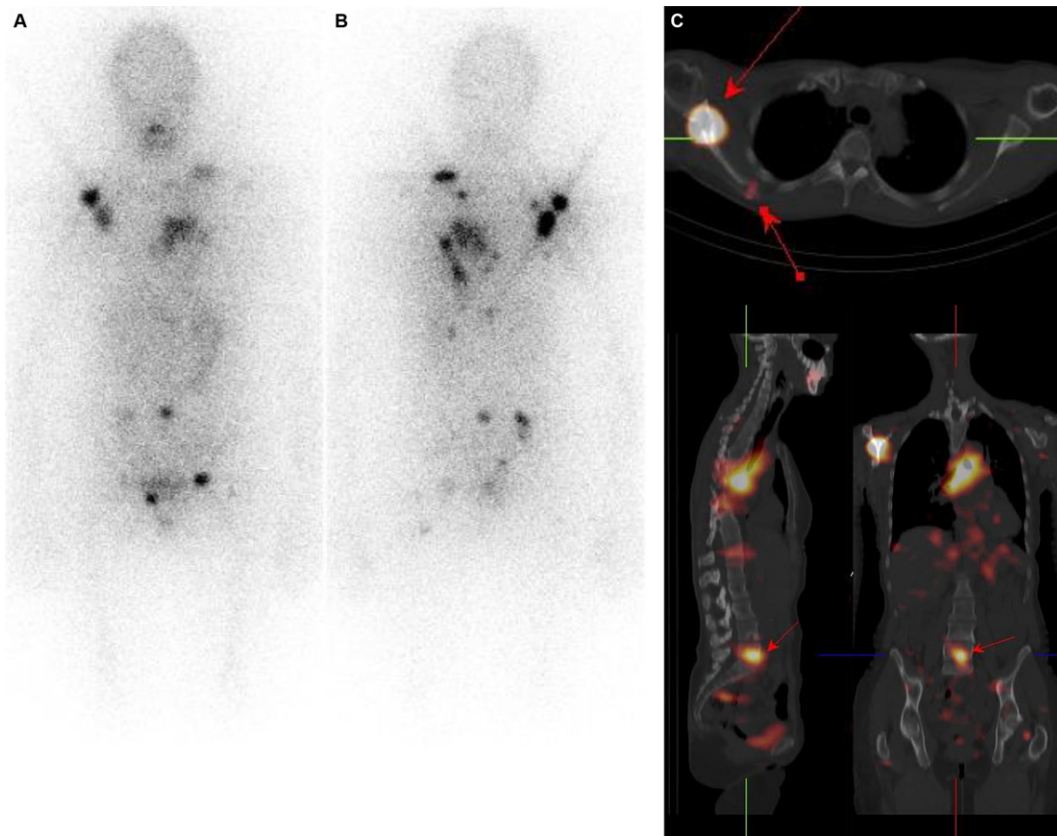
Post-therapy ^{131}I WBS (A, anterior; B, posterior views) and SPECT/CT (C) in a 50 years old female affected by papillary thyroid carcinoma (pT2 N1b) showing multiple visceral and skeletal radioiodine-avid metastases.
